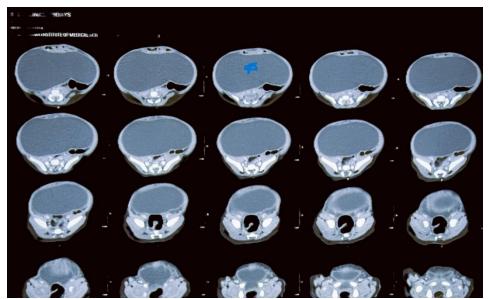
Abdomino-pelvic CT scan showed a 11x11x5.5 cm sized, non-enhancing, thin-walled, fluid-filled, cystic lesion (blue asterisk) in the lower abdomen.
